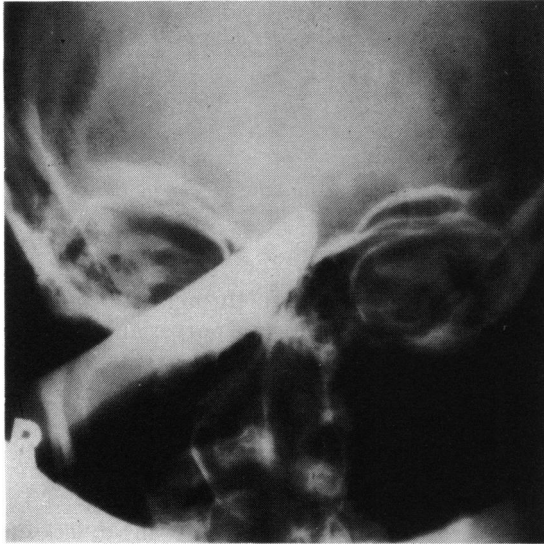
Anteroposterior skull radiograph.
